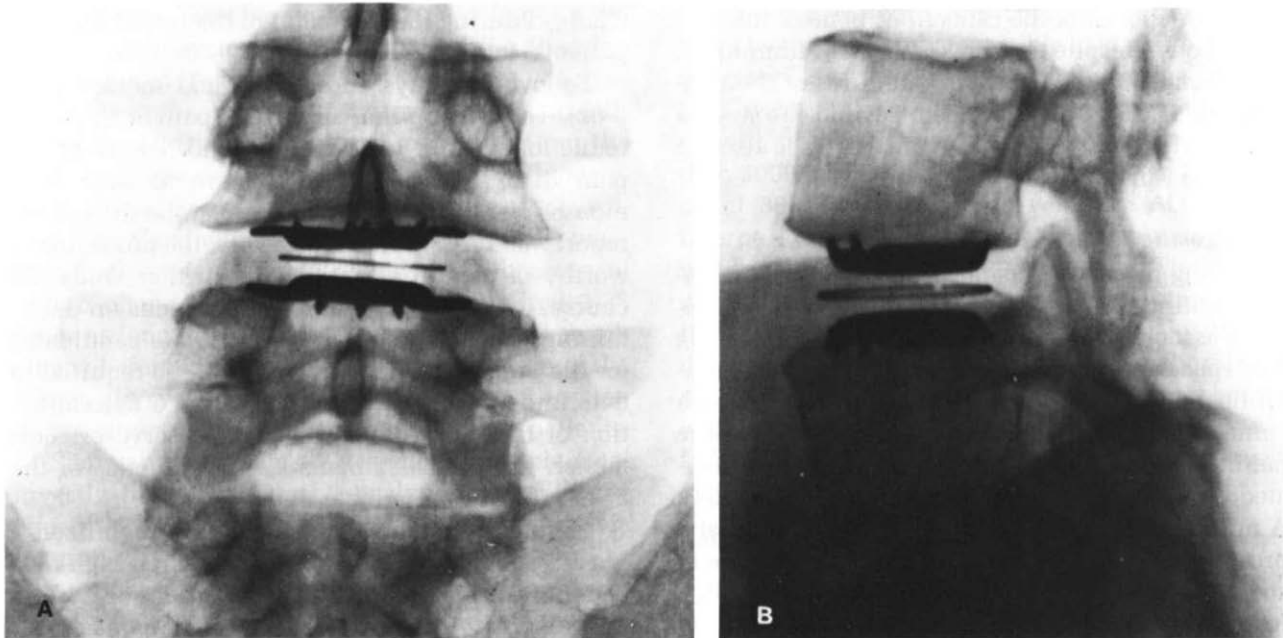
(A) Anteroposterior view of intervertebral disc prosthesis. This is basically composed of a plastic biconvex disc articulating with a concave metal component imbedded in each end-plate and/or subchondral bone. The metal discs can be seen, and the ring between them identifies the plastic component. (B) The components are shown here on a lateral radiograph. (Courtesy of Professor H. Zippel.)
